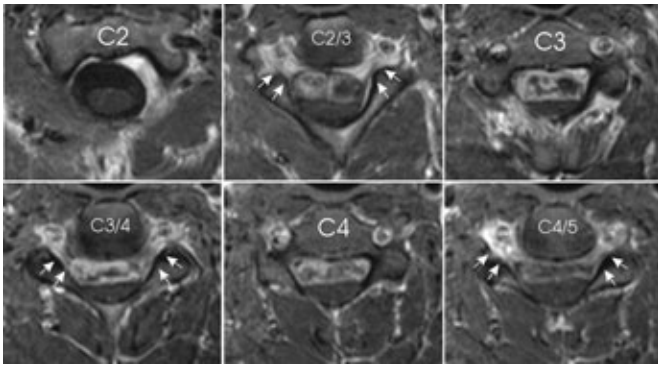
Axial, contrast enhanced T1 weighted magnetic resonance images between C2 and C5 demonstrated an intradural extra-axial tumor in the anterior spinal canal. The lesion was located in the midline and the spinal cord was displaced posteriorly without any lateral displacement or rotation. Posterior access would require partial removal of the lateral masses bilaterally. Arrows indicate the C3, C4 and C5 nerve root foramina which were not involved or widened by the tumor.
